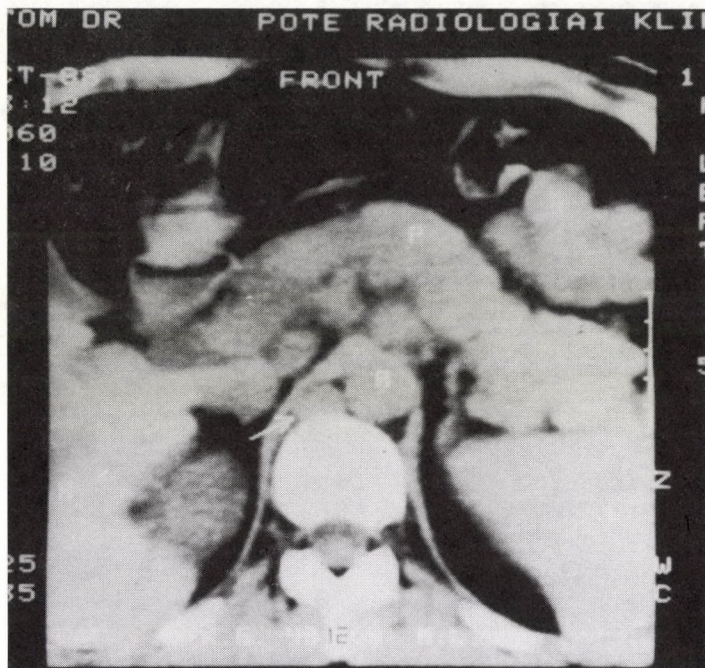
CT scan demonstrates an enlarged lymph node in the retrocrural area (arrow), right to the aorta (A). This region remains hidden when conventional imaging methods or ultrasonography is used
